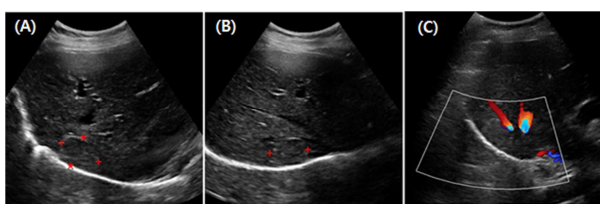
Ultrasonography images of hepatic hemangioma. (A) Ultrasound hyperechoic image with increased around(+) (B) Ultrasound hyperechoic image (C) color Doppler.
